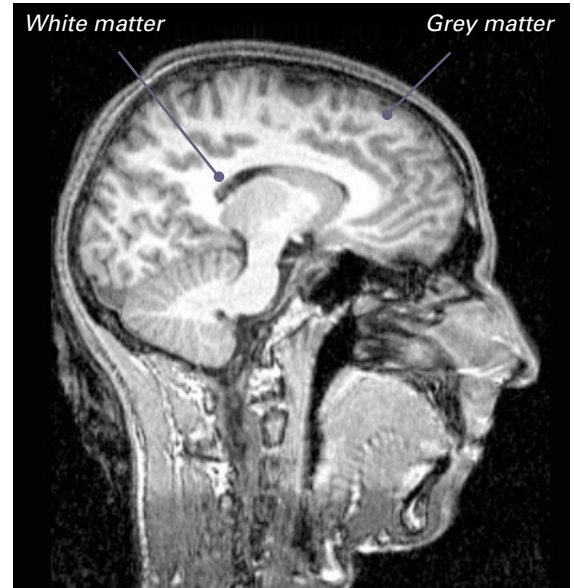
A structural MRI scan of the author's brain showing white and grey matter
